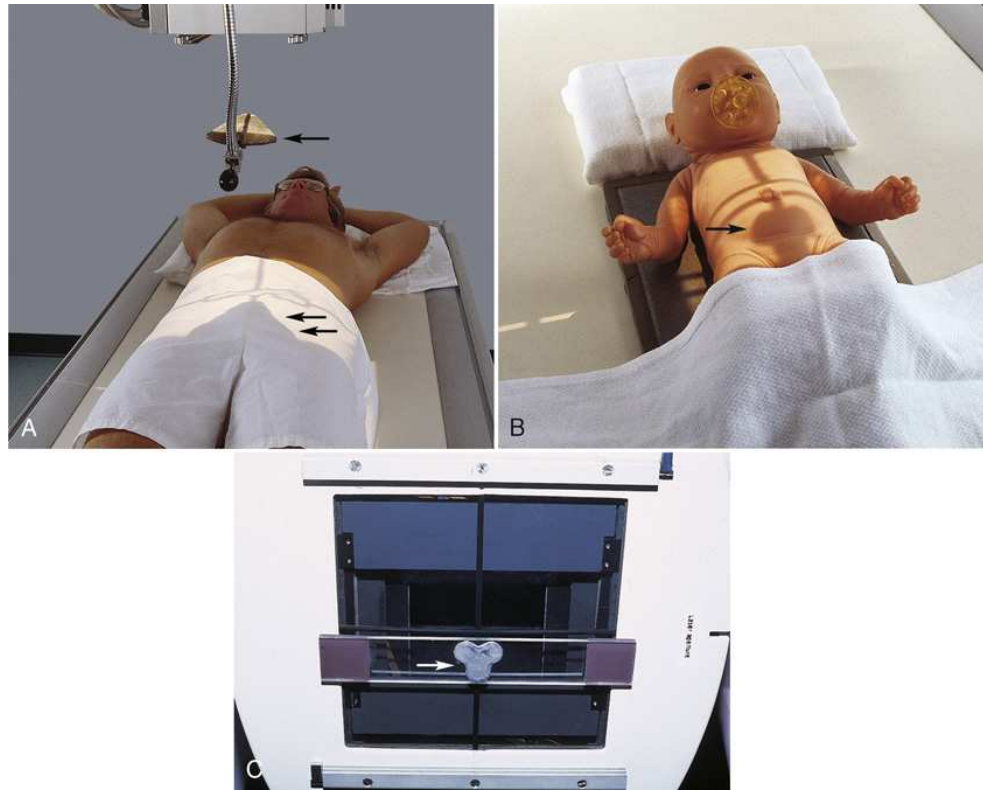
(A) Shadow shield used on a male patient. Triangular lead device (*arrow*) is hung from the x-ray tube and is positioned so that its shadow falls on the gonads (*double arrows*). (B) Shadow shield used on a female infant. Cloverleaf shield is positioned under the collimator with magnets so that its shadow falls over the gonads (*arrow*). (C) Cloverleaf-shaped shadow shield (*arrow*) positioned under the collimator with magnets.
